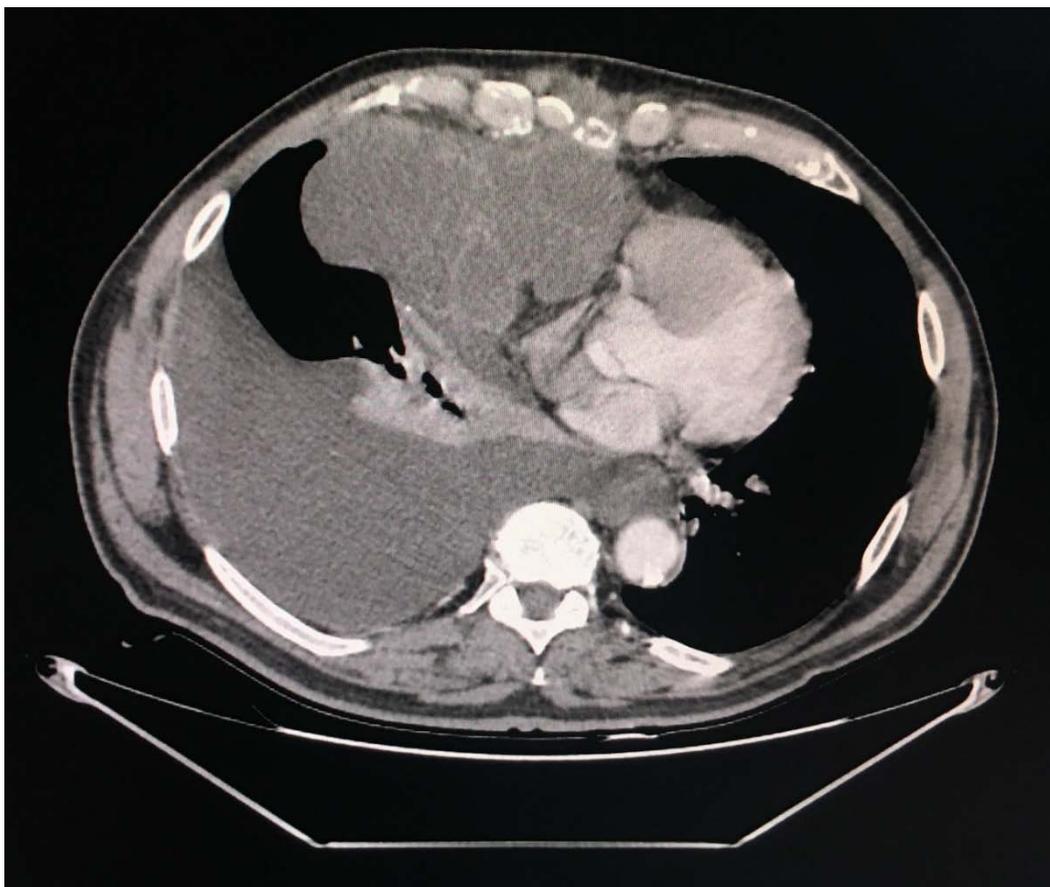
Computed Tomography of thorax evidencing a large expansive lesion measuring approximately 10 cm in the right anteroinferior thoracic wall
